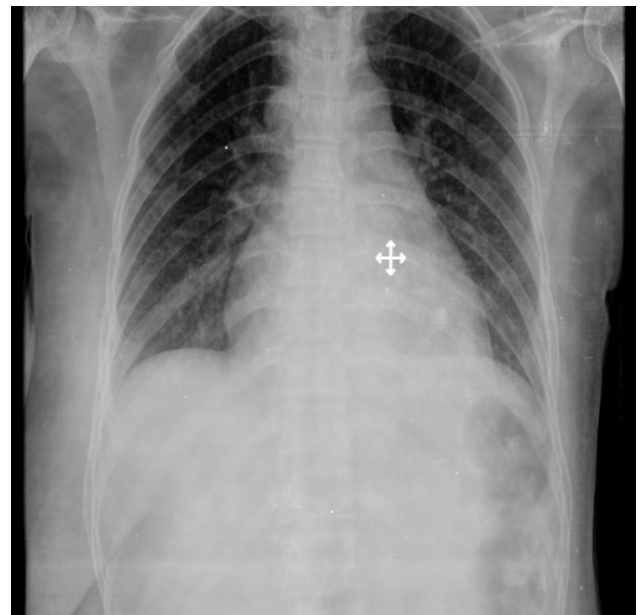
Chest x-ray after mastectomy without arechymal and rib involvement.
